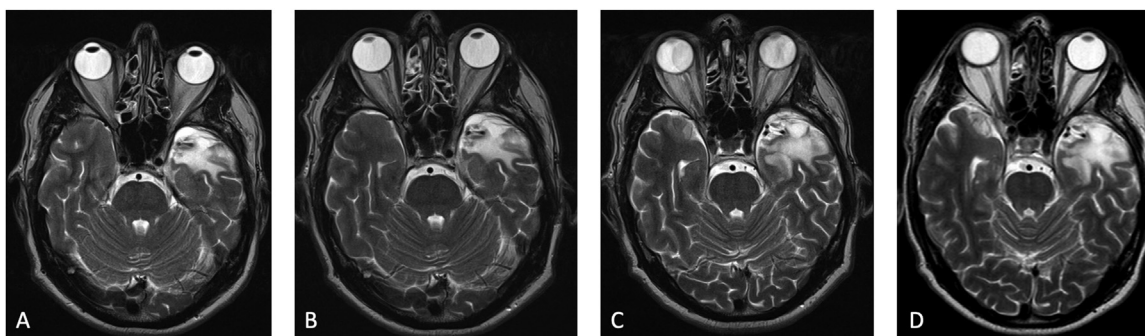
Evolution of left temporal brain structures shown on T2 magnetic resonance imaging studies: (A) 14.11.2011, (B) 06.11.2013, (C) 20.02.2016, (D) 15.02.2018.
